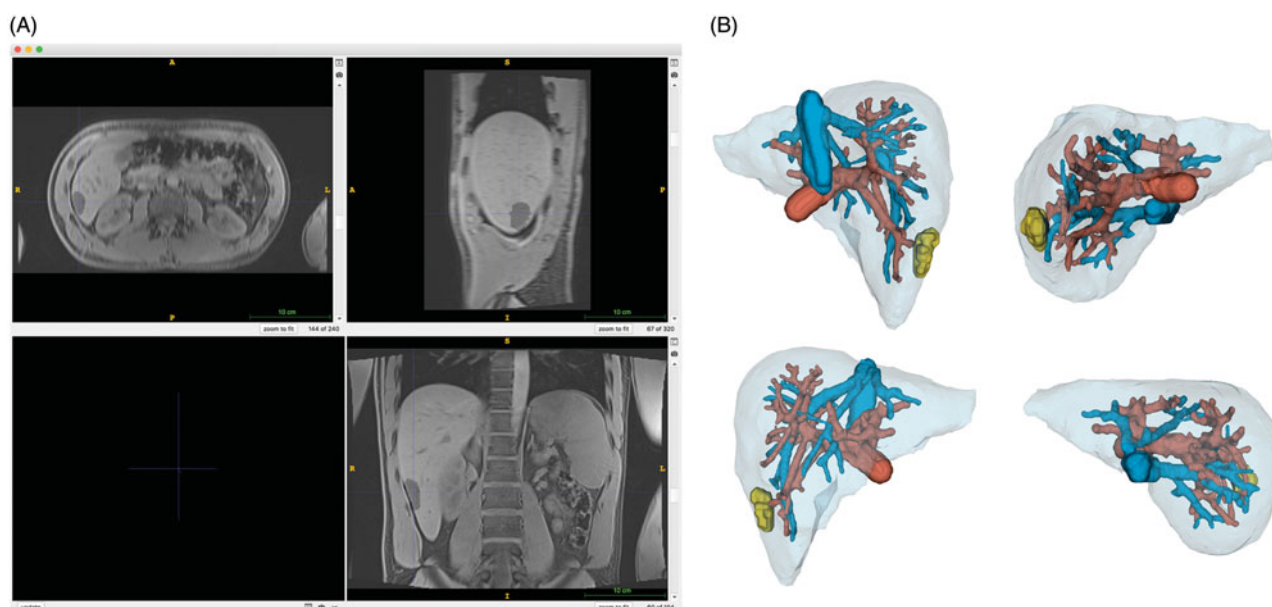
MRI image with a superimposed lesion. (A) 3D model of a liver with parenchyma, portal and hepatic veins as well as a lesion. (B).
